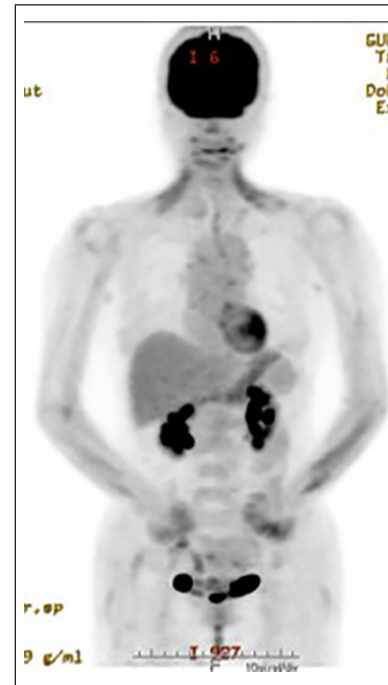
Disappearance of FDG accumulation during the subsequent patient follow-up.
